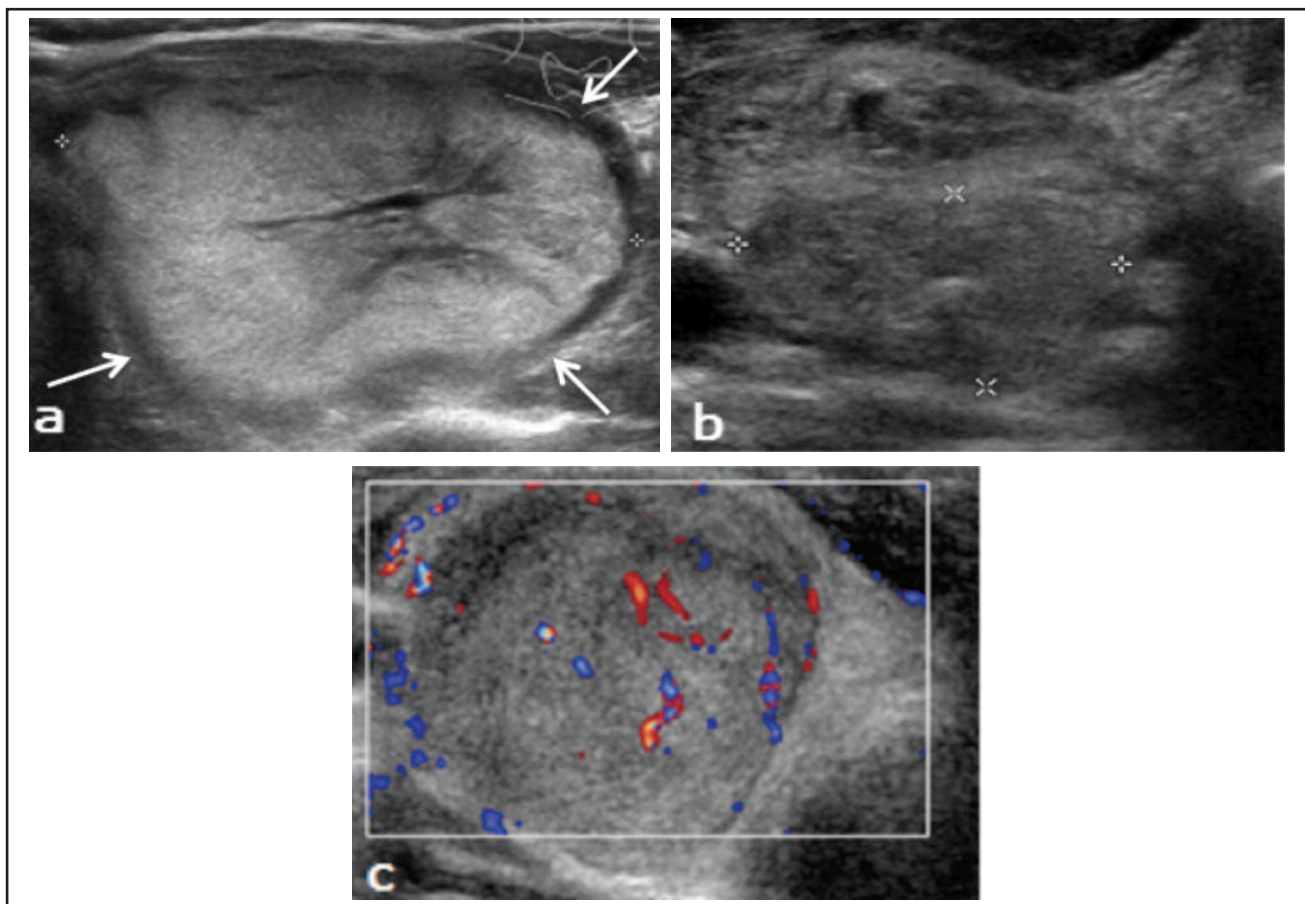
U3 category, indeterminate/ equivocal- (a) A hyperechoic, predominantly solid nodule with central linear cystic component, which has regular margins and a regular halo (white arrows) is considered indeterminate regarding its risk of malignancy. (b) A nodule containing an equivocal echogenic focus is indeterminate. (c) Doppler assessment of an indeterminate nodule showing mixed vascularity, which consists of both peripheral and intra-nodular vascularity.
